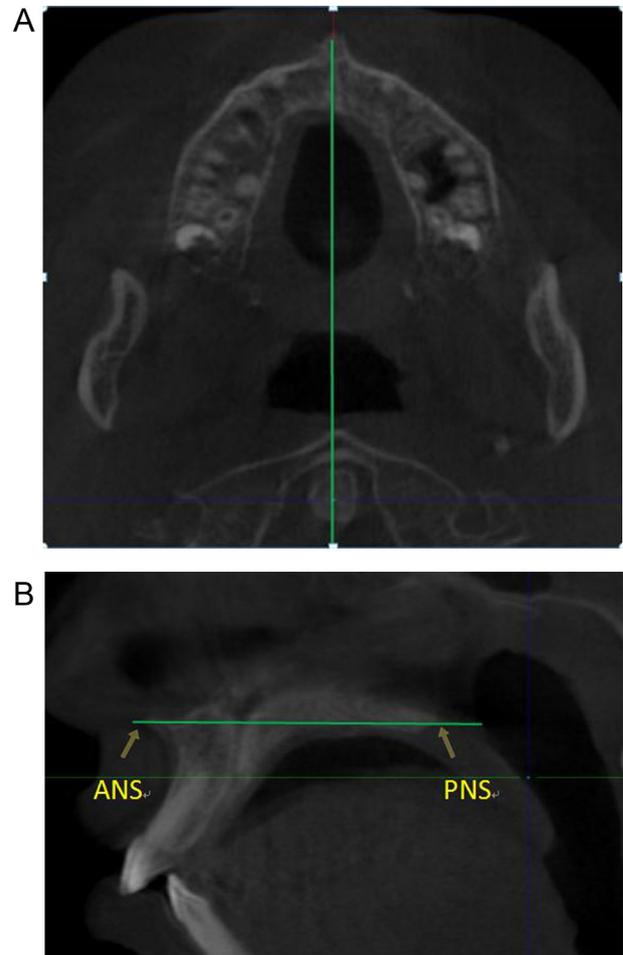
The figures show how the CBCT images were oriented. (A) The midsagittal plane was adjusted on the line connecting the midpoints of the nasopalatine foramen and the spine. (B) The axial plane was adjusted on the palatal plane extending from anterior nasal spine (ANS) to posterior nasal spine (PNS).
